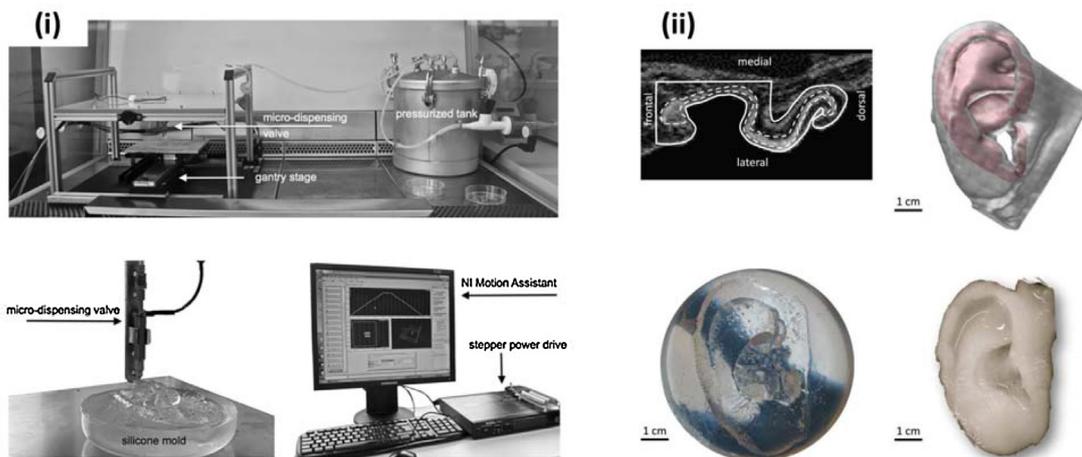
Biofabrication of a patient-specific ear-shaped BC implant. (i) The bioprinter consists of a high-precision motion system and a microdispensing system. (ii) Transverse slice isolated from a spoiled gradient-echo MRI scan of the volunteer's left ear. The 3D BC implant prototype was fabricated in the shape of the whole outer ear.
